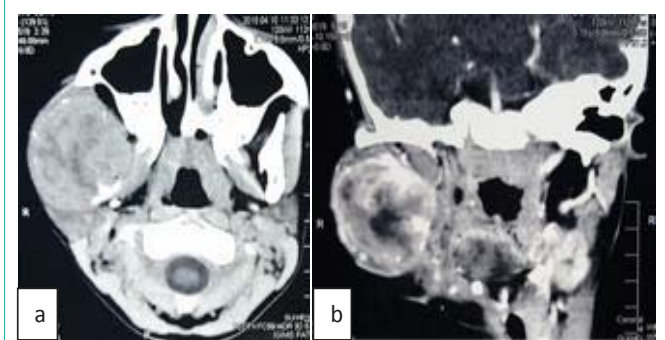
a,b) CT Scan Axial and coronal view showing recurrent lesion involving ramus and head of mandible and extension in TM joint and temporal fossa.
